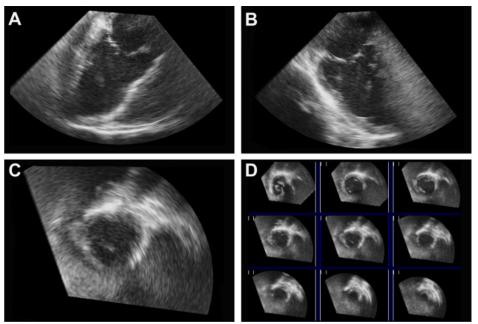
Full Volume 3D-TEE Images of the Left Ventricle. 3D-TEE recordings of the left ventricle one week after acute myocardial infarction (75 minutes) and reperfusion. Perpendicular long-axis images of the left atrium and left ventricle can be observed in the upper half panel (A, B). A magnified example (C) of multiple cross-sectional images (D) of the left ventricle is displayed in the lower half panel. 3D-TEE: three-dimensional transesophageal echocardiography. Please click here to view a larger version of this figure.
